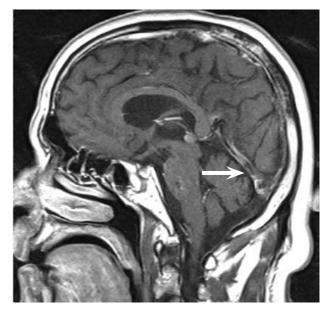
Gadolinium-enhanced MRI images of the brain, focused on the pineal gland (sagittal view). The arrow indicates a small lesion in the area of the base of the brain.
